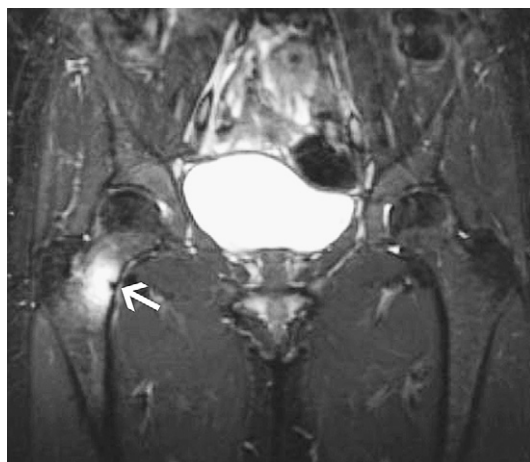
Coronal fat-saturated T2-weighted image in a 30-year-old female runner shows bone marrow hyperintensity consistent with edema, which surrounds a hypointense line at the inferior aspect of the right femoral neck (*arrow*) compatible with a stress fracture.
